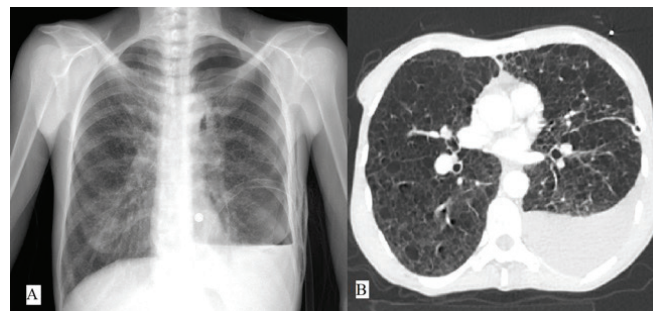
Posteroanterior chest X-ray showing left hydropneumothorax and chest tube (A), thoracic tomography revealed diffuse, thin-wall cystic lesions in both lung parenchyma and left pleural effusion (B).
